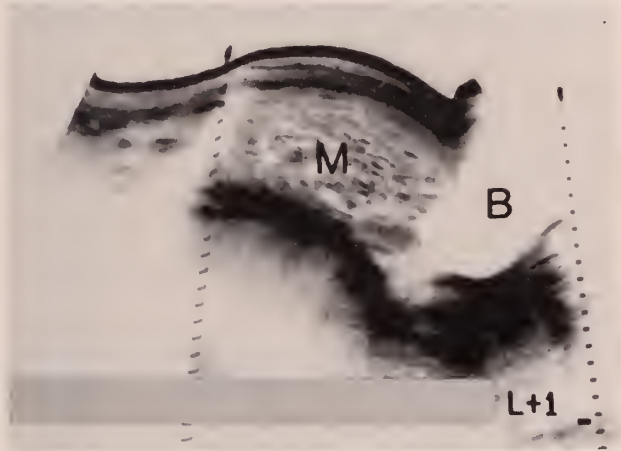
Longitudinal gray scale ultrasound scan of an uncomplicated hydatidiform mole (M). (B) indicates bladder.
